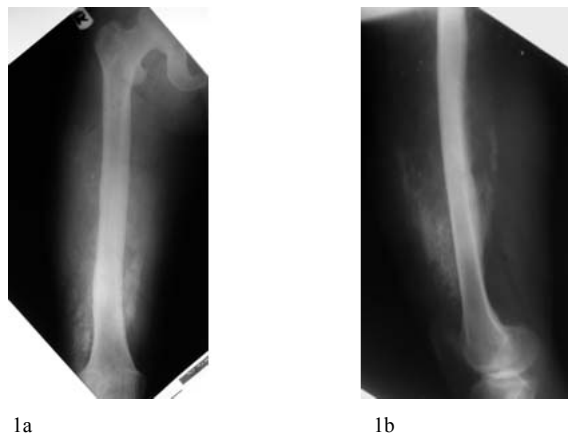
AP (1a) and lateral (1b) radiographs show an osseous soft tissue mass in the anterior aspect of the right femur with linear and streak-like ossification.
